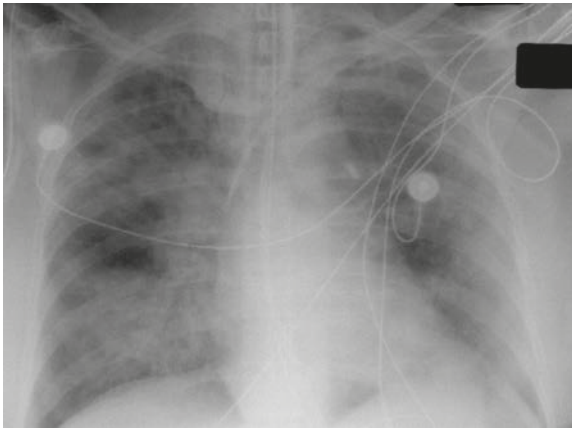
Frontal chest radiograph of a patient with ARDS.
